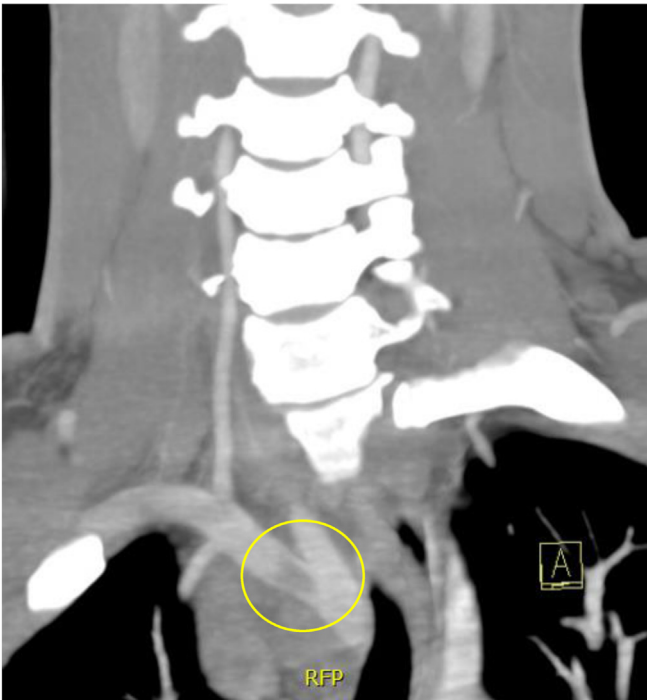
Computed tomography angiogram showing thrombus (yellow circle) within the right subclavian artery distal to the pseudoaneurysm.
